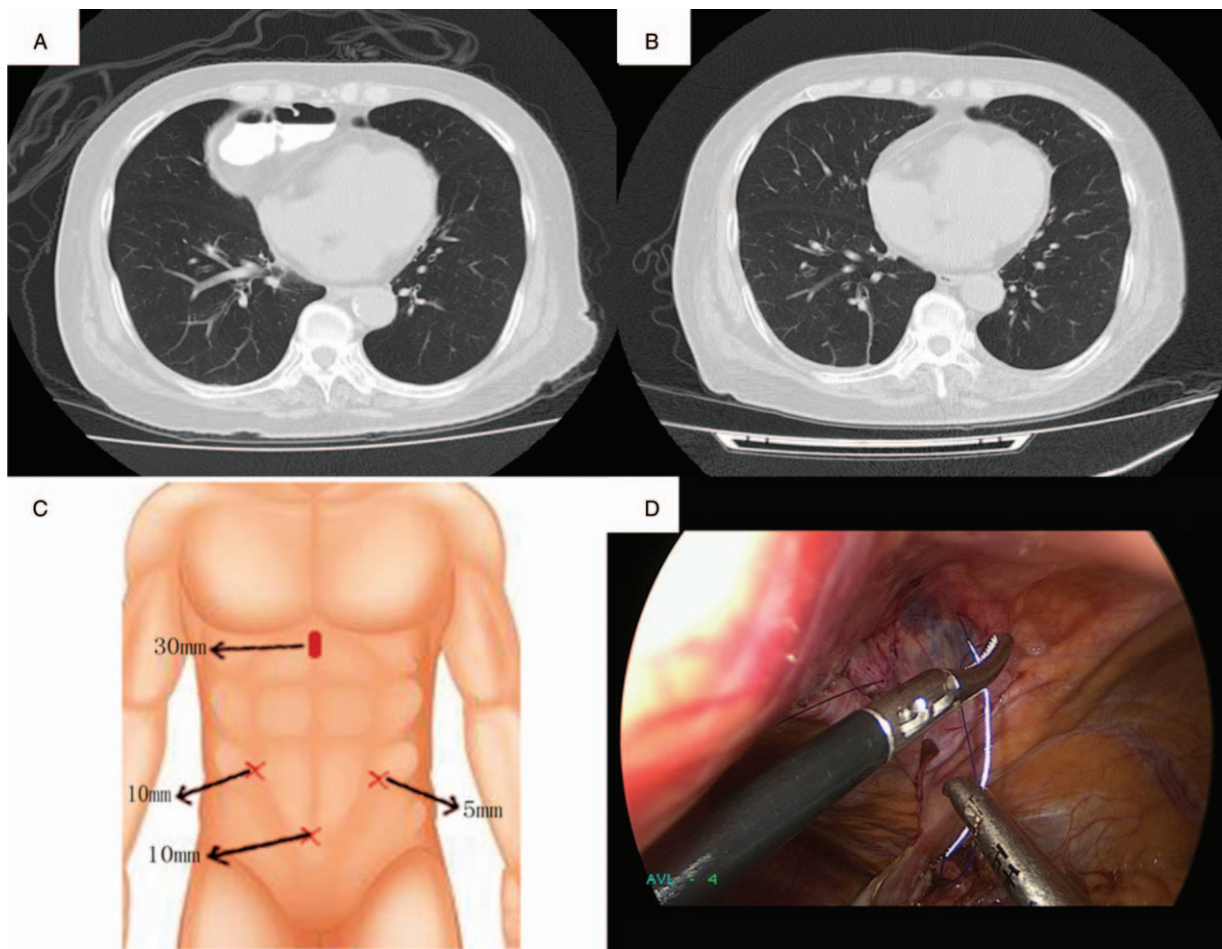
(A) A CT scan showed right side parasternal diaphragmatic hernia and the herniated mass was the colon. (B) A CT examination obtained 2 days after surgery showed that hernial component was completely removed from the pleural space. (C) Trocar and xiphoid incision positioning. (D) Straighten the needle.
